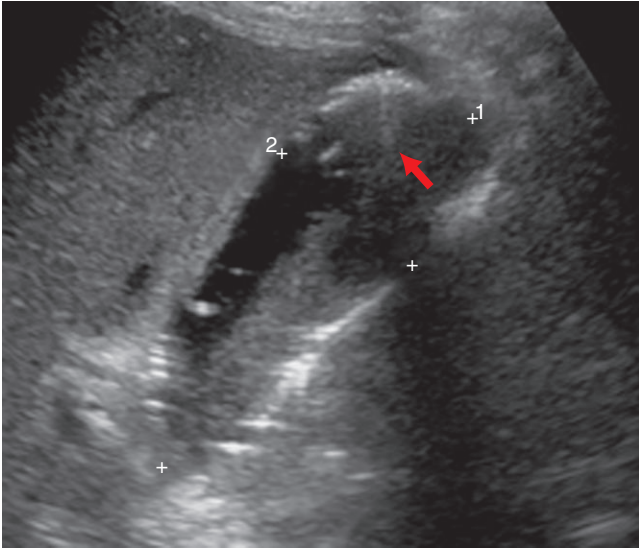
The sagittal sonographic image of the gallbladder shows an echogenic gallbladder wall with dirty shadowing posteriorly (arrow). There are also a few echogenic foci within the lumen consistent with intraluminal air and there is sludge.
